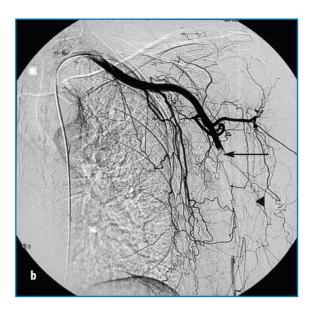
a Chest X-ray of patient 3. Cardiomegaly in a young HIV-infected woman with peripheral vasculitis of the arms. b Arteriography of the left arm. Note the thrombosis in the left humeral artery (*arrow*) and the development of a collateral network of arteries to supply the arm (*arrowhead*). c A typical long inflammatory stenosis in the right subclavian artery (*arrow*). This image was obtained in a non-HIV-infected patient with giant-cell arteritis and is similar to that of the stenosis that developed in our case 3
